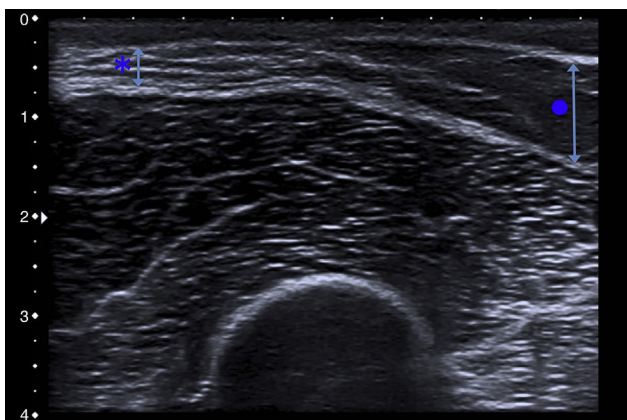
Cutaneous ultrasound revealed a marked loss of subcutaneous tissue (asterisk and short arrow) in comparison to the healthy adjacent subcutaneous tissue (circle and long arrow).
